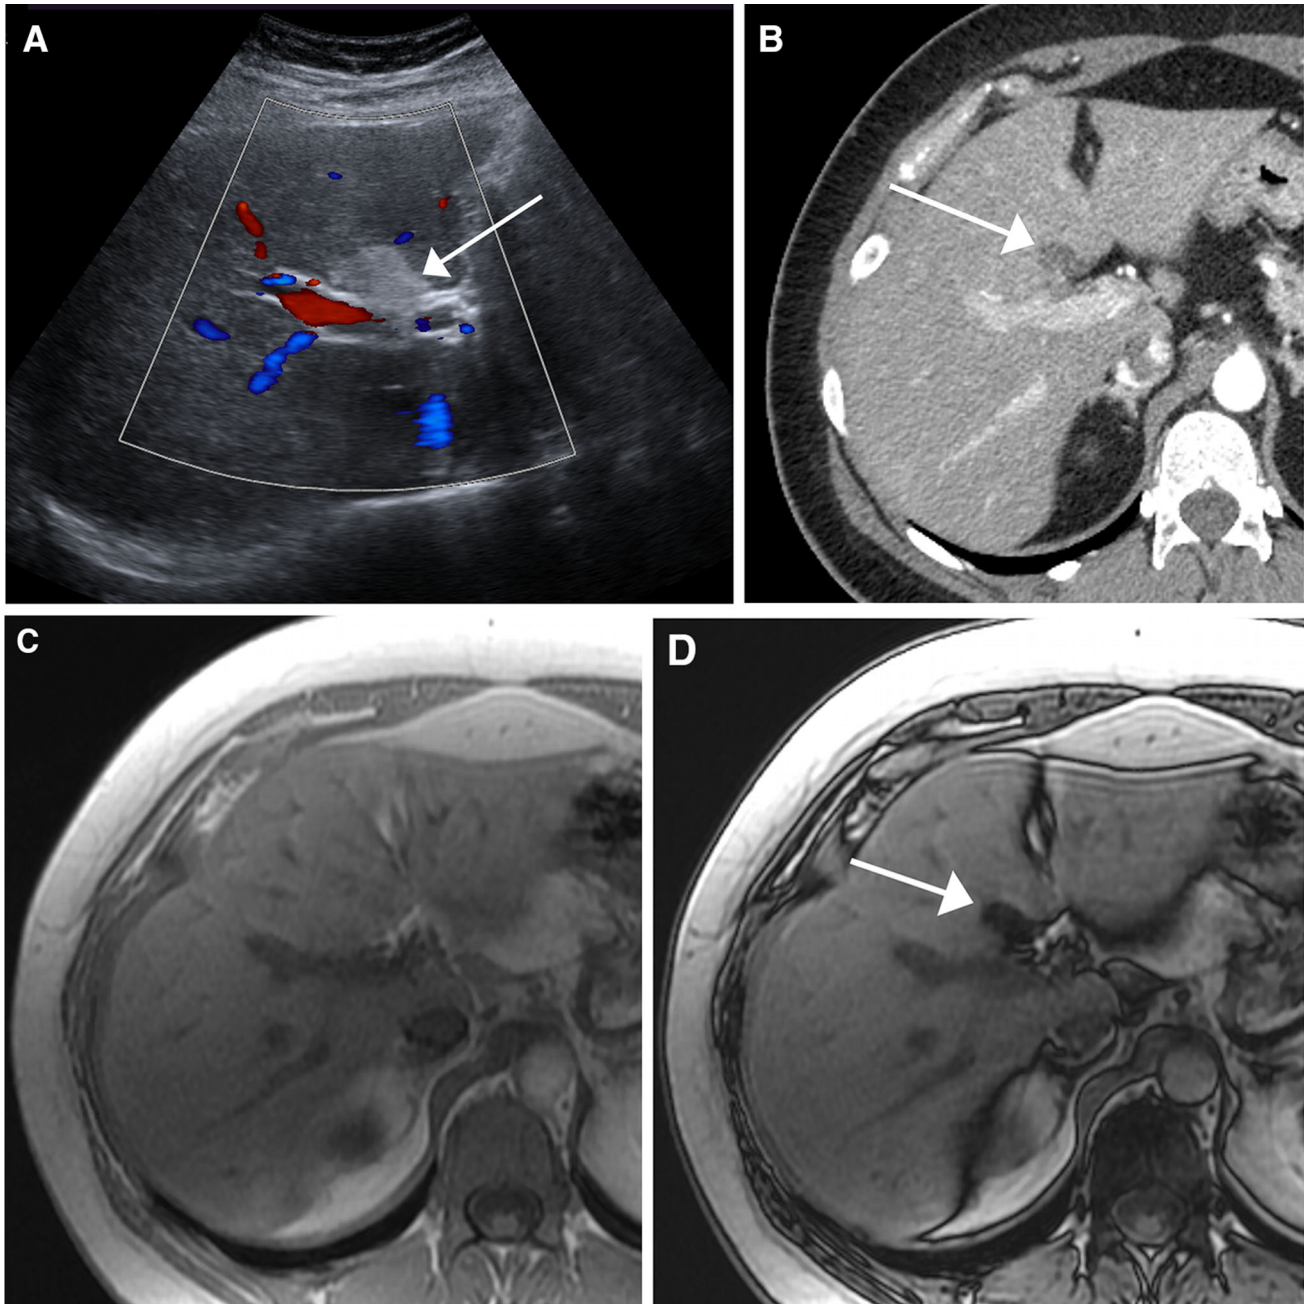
LI-RADS US-1: negative. Example of US-1 observation on screening exam in a 36-year-old female with cirrhosis secondary to autoimmune hepatitis. A Focal echogenic geographic area on ultrasound, located near porta hepatis (*arrow*). B CT with contrast shows corresponding area to be
